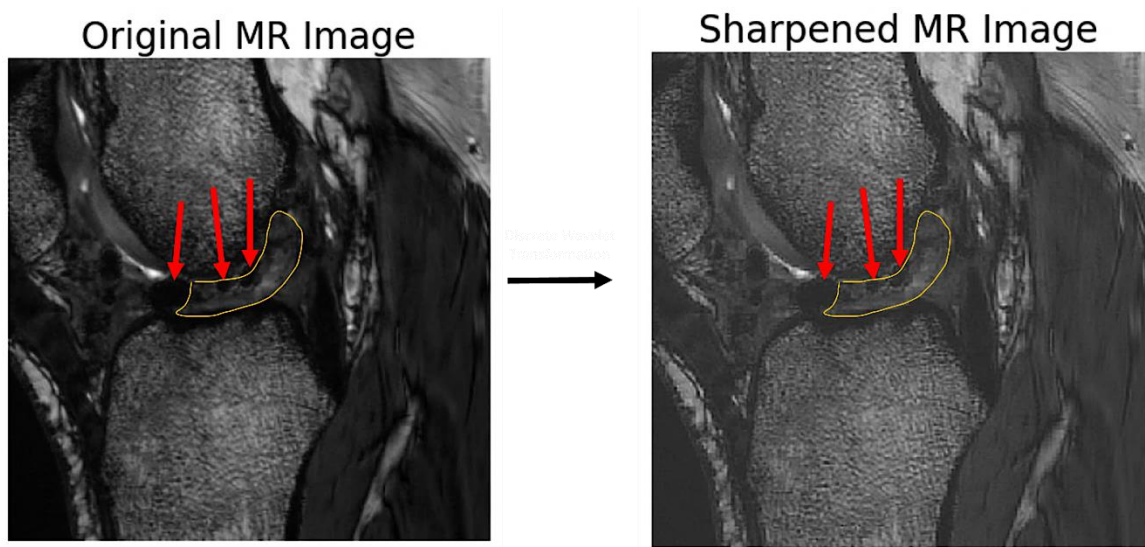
Original MR image before DWT and the sharpened MR image after DWT with red arrows pointing to metallic artifacts along the ACL (outlined in yellow).
